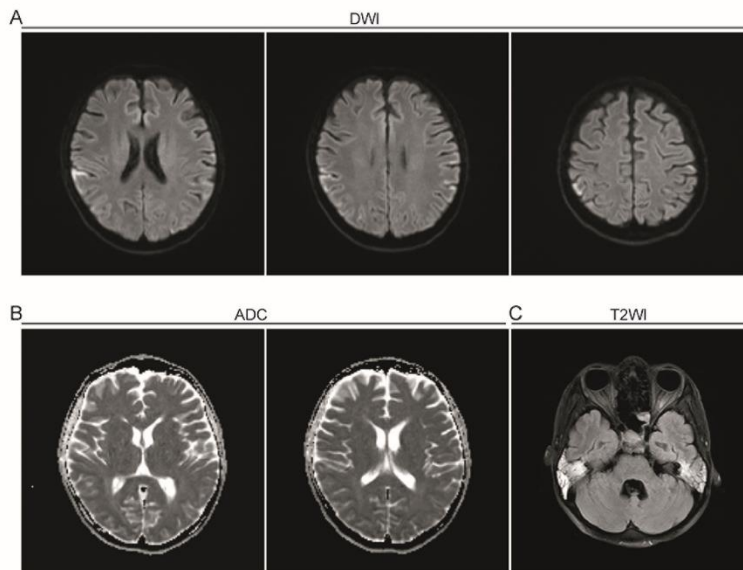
Sequential changes in MRI. (A, B) DWI showed a linear of bilateral and symmetrical signal in high intensity at the level of temporo-parietal-occipital cortex (A) with reduced ADC map values (B). (C) T2WI image demonstrated quasi circle high intensity signal in the left ethmoidal sinus
